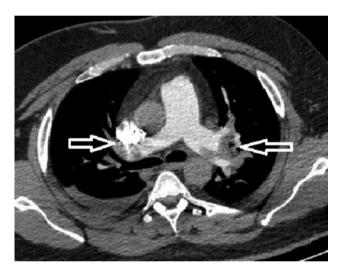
CT images revealed pulmonary emboli in right and left pulmonary arteries (red arrows)
